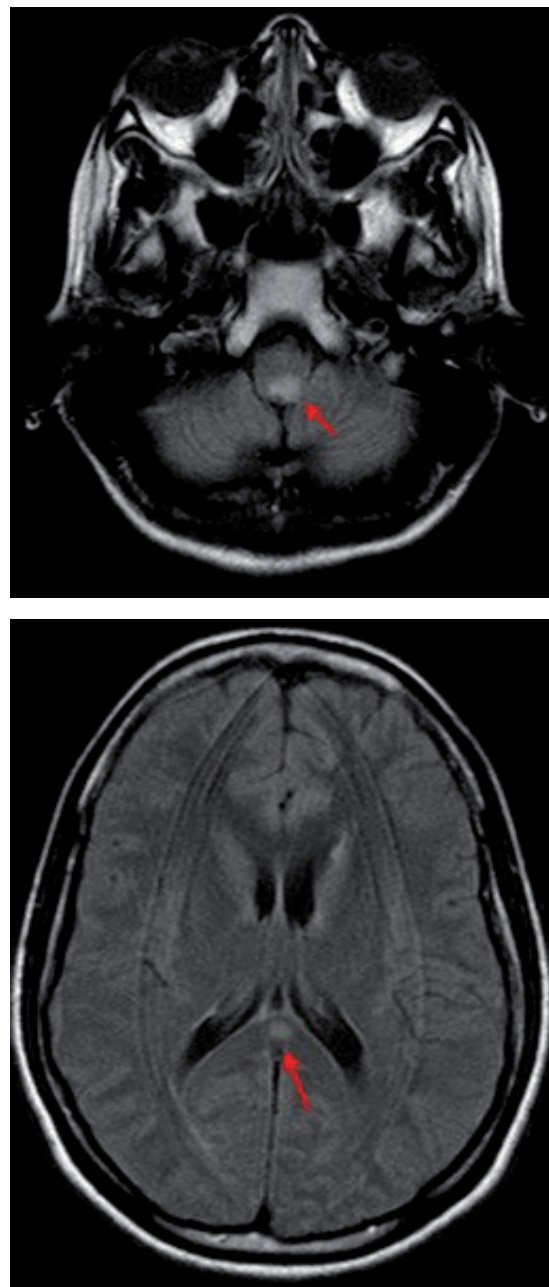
Axial FLAIR MRI sequence of the brain again shows hyperintense lesion in the dorsal medulla and in the splenium of corpus callosum.
